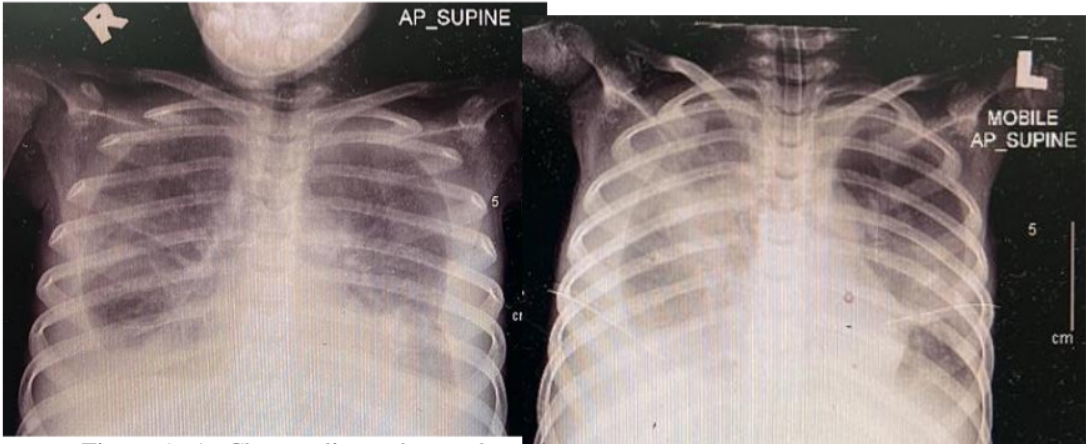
A. Chest radiograph pre-chest tube insertion (left) B. Chest radiograph post-chest tube insertion (right).
